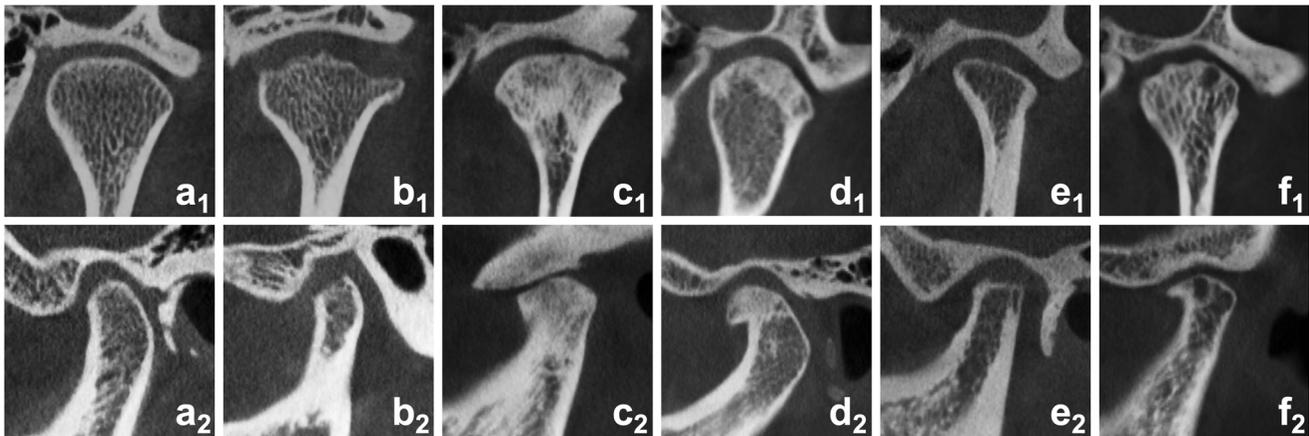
CBCT images of TMJs without and with DJD: (a) healthy joint, (b) erosion [decreased density of cortical bone and subcortical bone], (c) sclerosis [increased density of cortical bone extending into bone marrow], (d) osteophyte [marginal bone outgrowth of the condyle], (e) deviation in the form [loss of convex condylar form], and (f) cyst-like lesion [well circumscribed osteolytic lesion in subcortical bone without cortical destruction]. (1) indicates the coronal reconstruction while (2) indicates the sagittal reconstruction.
